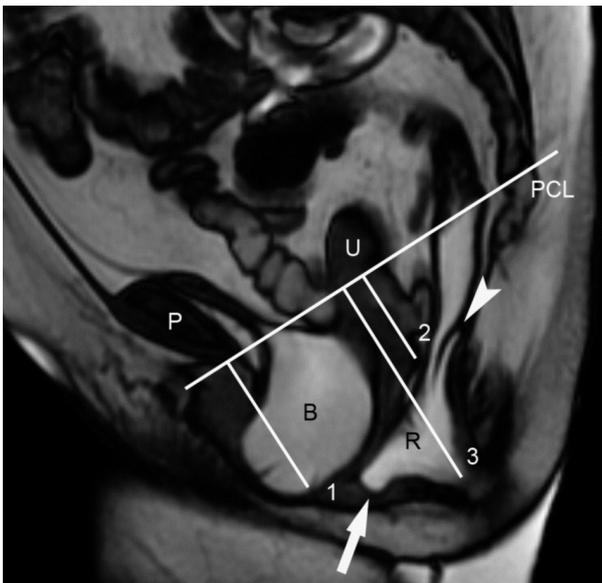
Midsagittal balanced steady state free precession T2-weighted MR image obtained during maximal straining shows a bulging of the whole pelvic floor with a moderate descent of the anterior compartment (1: 5.5 cm) and the middle compartment (2: 4 cm) and a large descent of the posterior compartment (3: 8 cm). In addition, a small anterior rectocele (arrow) and intussusception of the posterior rectal wall (arrowhead) are seen. P=symphysis pubis, B=bladder, U=uterus, R=rectum, PCL=pubococcygeal line.
